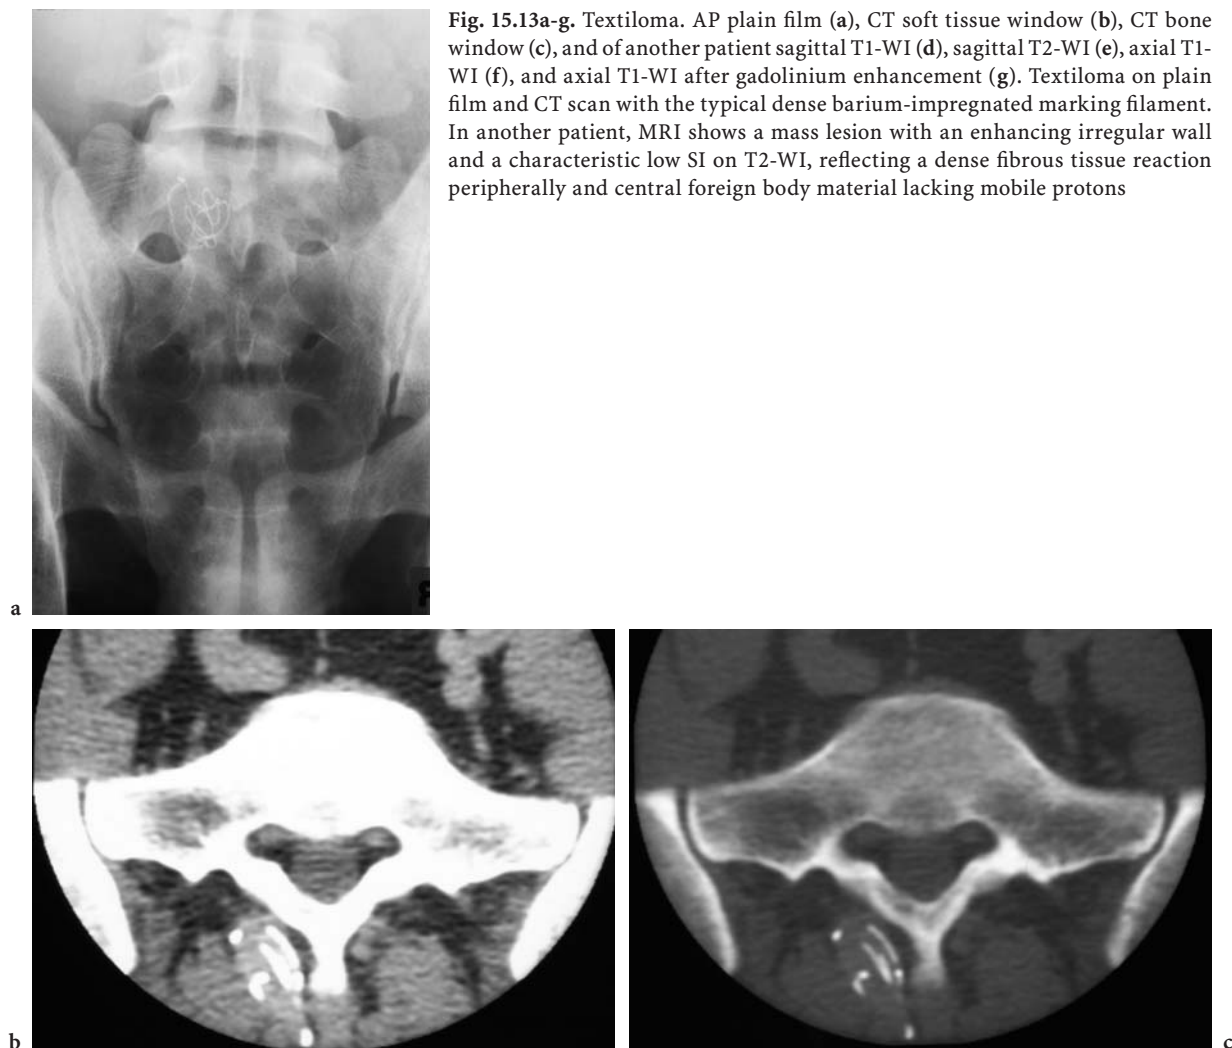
Textiloma. AP plain film (a), CT soft tissue window (b), CT bone window (c), and of another patient sagittal T1-WI (d), sagittal T2-WI (e), axial T1-WI (f), and axial T1-WI after gadolinium enhancement (g). Textiloma on plain film and CT scan with the typical dense barium-impregnated marking filament. In another patient, MRI shows a mass lesion with an enhancing irregular wall and a characteristic low SI on T2-WI, reflecting a dense fibrous tissue reaction peripherally and central foreign body material lacking mobile protons
